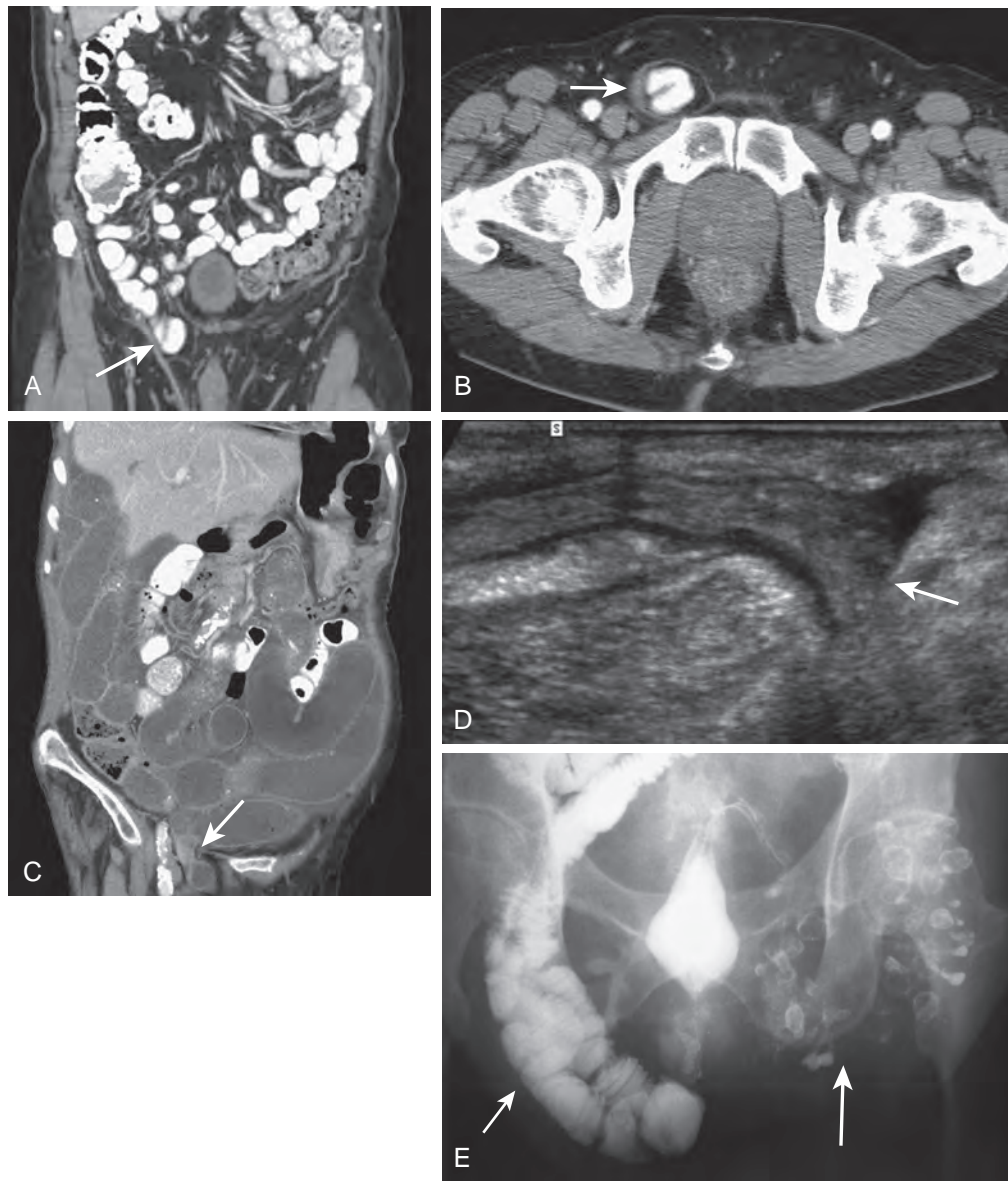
Inguinal hernia. A. Coronal, reformatted CT image shows a nonobstructing, right inguinal hernia containing small bowel (arrow). B. An axial image shows the herniated segment of ileum (arrow). C. Coronal, reformatted CT image reveals an obstructing, right inguinal hernia containing a small segment of ileum (arrow). D. Sagittal sonogram in a different patient demonstrates an inguinal hernia containing fat, fluid, and gut (arrow). E. Barium enema examination demonstrates herniation of the distal ileum into the right scrotum (small arrow). There is herniation of the sigmoid colon into a left inguinal hernia (large arrow).
